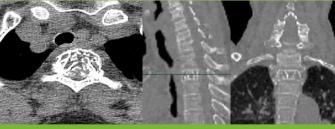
Preoperative CT demonstrating classical polka dot appearance of vertebral hemangioma
